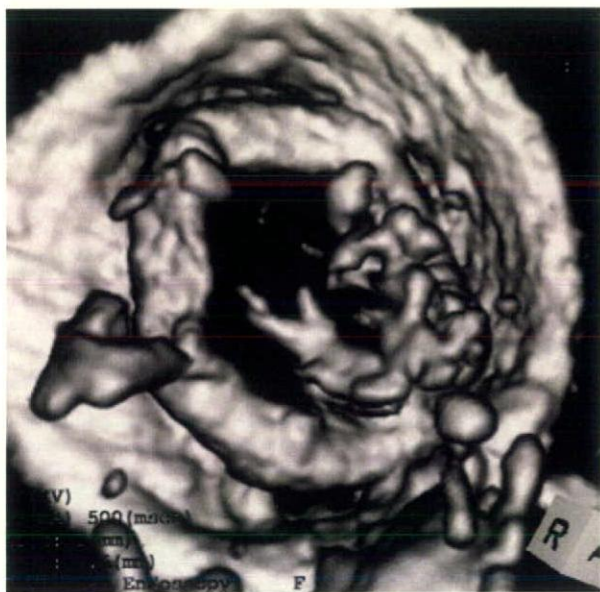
Computed tomographic scan demonstrates stenotic aortic lumen caused by an abnormal projection into the aortic lumen at the proximal anastomosis.
